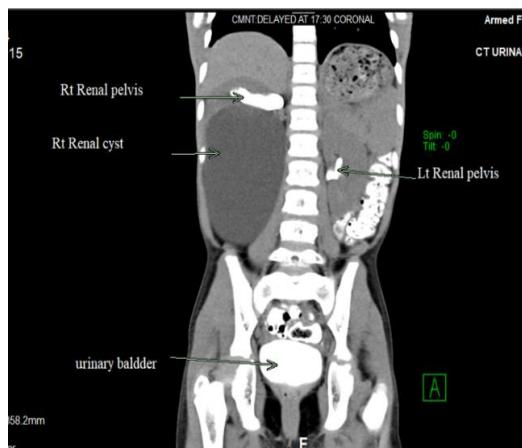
Coronal view CT scan urinary Tract before surgery
